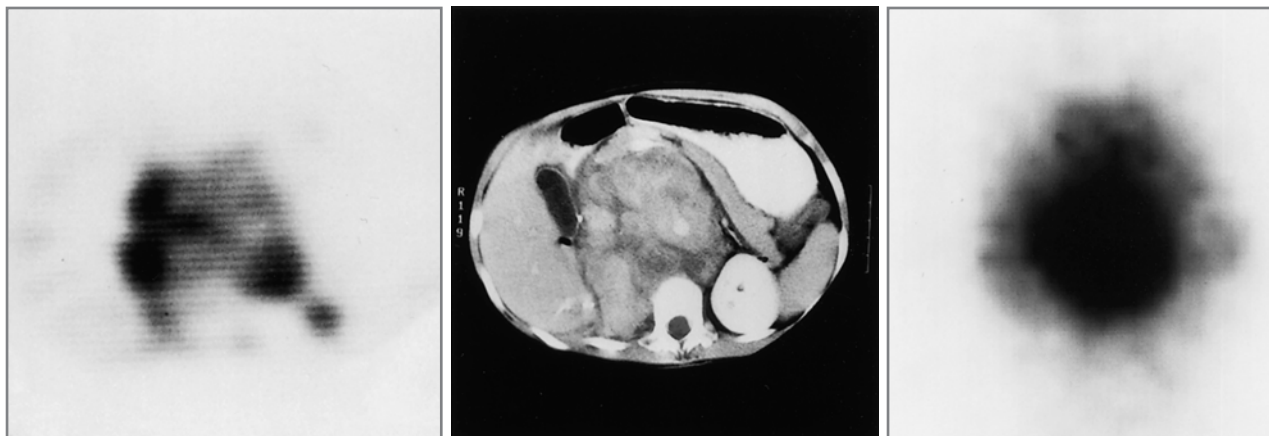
Uptake of FDG within ganglioneuroma. The patient presented at age 2 years with intractable diarrhea and was found to have a nonresectable 10-cm abdominal mass containing mostly stroma and rare elements of neuroblastoma. She received radiotherapy, chemotherapy, and subsequent surgical debulking. MIBG scans showed persistent abdominal uptake. The patient eventually received therapy with [^{131}I]MIBG. Surgical debulking was again repeated. Multiple resected portions of the tumor contained only mature stroma and no neuroblastoma. She did well and returned for reevaluation 16 months later. *Left panel:* Transverse image of PET scan obtained 60 min following injection of FDG shows heterogeneous increased uptake of FDG in midabdomen. *Middle panel:* CT scan of the abdomen demonstrates the very large abdominal mass. *Right panel:* Anterior image of [^{131}I]MIBG scan 48 h after injection shows extensive, intense uptake in the abdomen, corresponding to the tumor. (Reprinted with permission from Shulkin BL, Hutchinson RJ, Castle VP, Yanik GA, Shapiro B, Sisson JC. Neuroblastoma: positron emission tomography with 2-[fluorine-18]-fluoro-2-deoxy-D-glucose compared with metaiodobenzylguanidine scintigraphy. *Radiology* 1996;199:743–750.)
